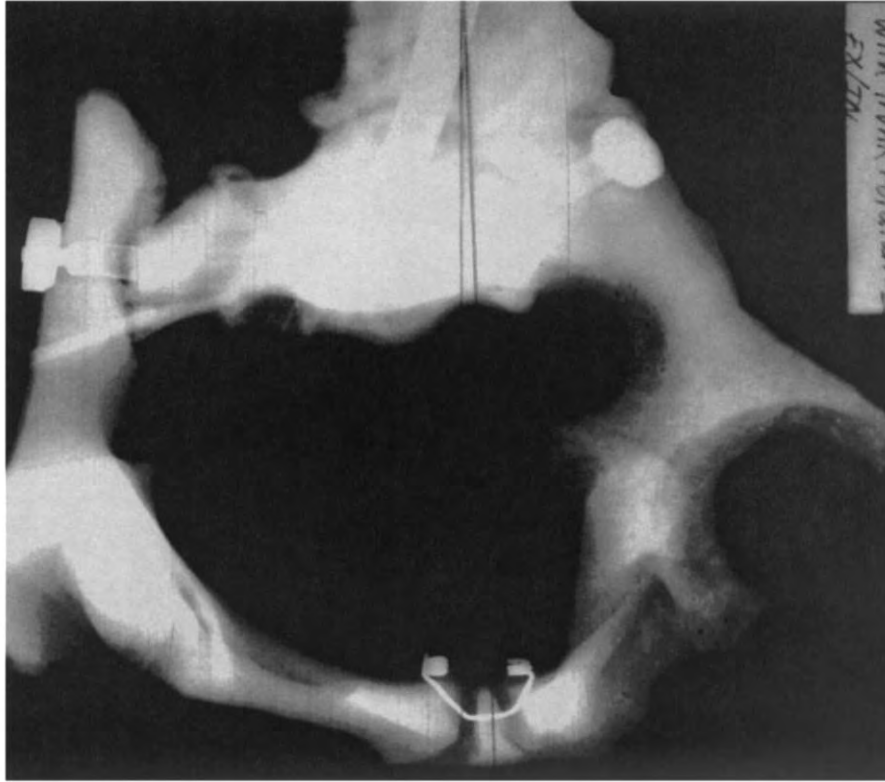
Ex/In sublaxated female pelvic bowl. (Model) S to I view. Note lack of symmetry, and distortion of roundness of the opening. Also note difference in space from centerline through pubic symphysis to right ilium. (Radiograph provided courtesy of Cherie Goble, DC.)
